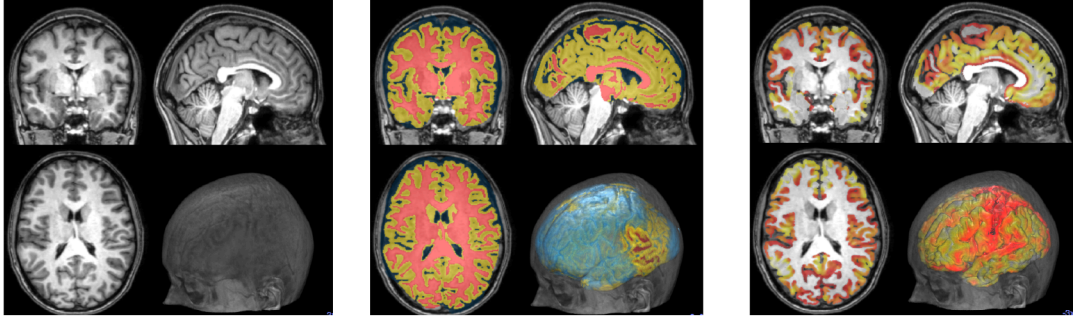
T1-weighted MRI image of a human brain (left), WM-GM segmentation in overlap (center), Cortical thickness image in jet map overlap (right).
